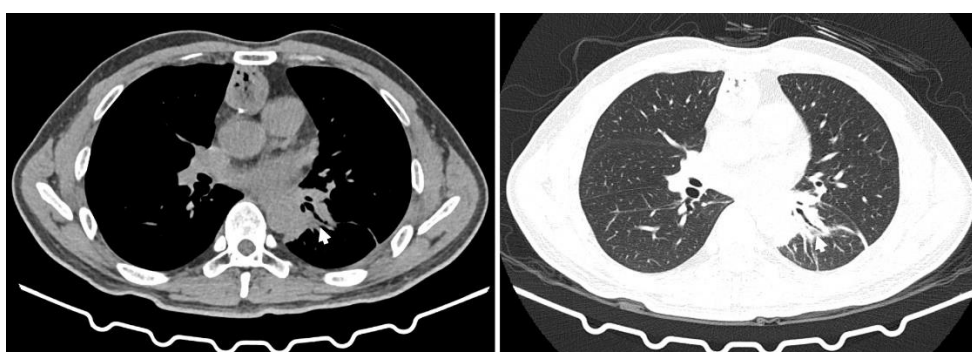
Axial non-contrast-enhanced CT images of the chest demonstrate a focal area of consolidation with surrounding ground-glass opacity (mediastinal window left panel, and lung window, right panel, arrows) in the left lower lobe, suggestive of either post-inflammatory change or malignant infiltration
